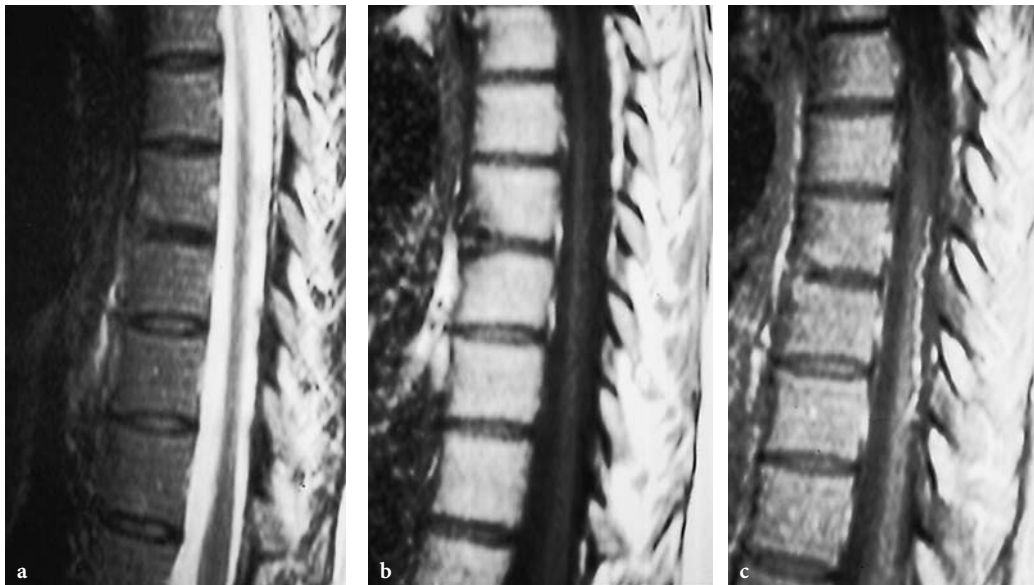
The MRI appearance of a Romanus lesion. a Sagittal fast spin-echo T2-weighted image. b Sagittal spin-echo T1-weighted image. c Sagittal spin-echo T1-weighted image after intravenous gadolinium contrast administration. Note focal anterior corner destruction and associated bone marrow edema at the thoracolumbar junction. There is contrast enhancement of the anterior corner lesions
